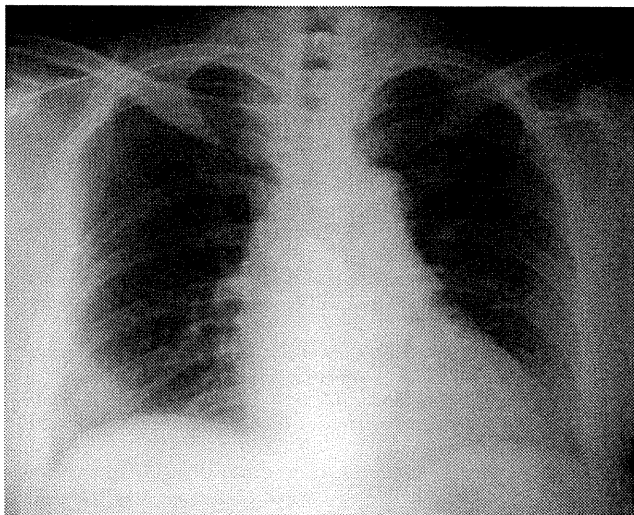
Plain chest radiograph of case 1 on day 50 (12 days after the removal of the noninvasive positive pressure ventilation device) demonstrating no recurrence of subarachnoid-pleural fistula.
